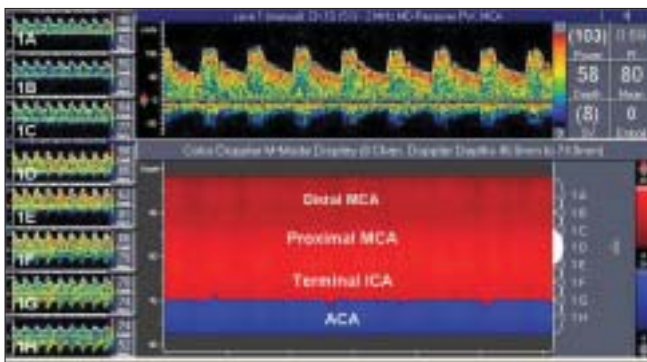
Normal transcranial Doppler using the temporal acoustic window. The appearance of the screen of Companion-III (Nicolet-Viasys). The upper frame represents the Doppler spectrum obtained from M1 MCA at a depth of 58 mm. M-mode signatures of distal MCA, proximal MCA, terminal ICA, and ipsilateral ACA are shown in the lower frame. The frames on the right side (1A to 1H) represent the Doppler spectra obtained simultaneously from 8 different depths between 46 to 74 mm
